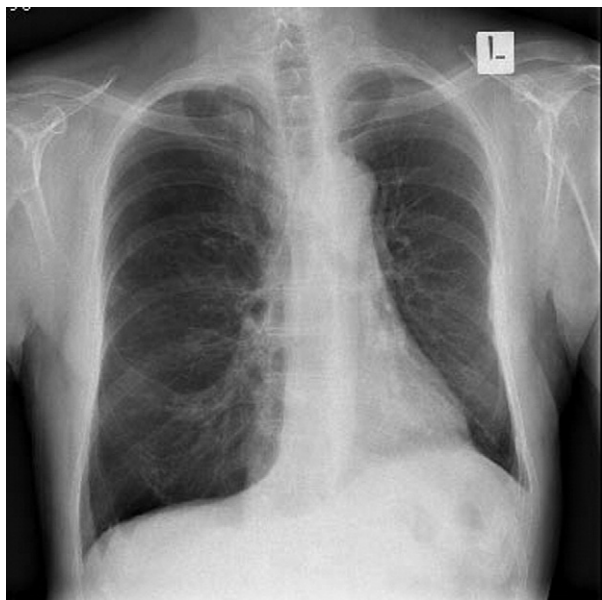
A preoperative chest radiograph shows severe emphysema with increased radiolucency in the right hemithorax.
